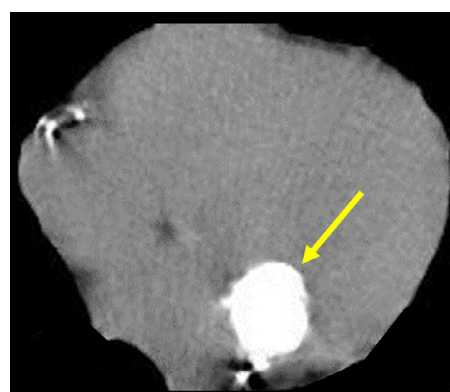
Retrospective review of a noncontrast CT scan performed 6 months earlier for pneumonia (7A) reveals prominent internal calcifications within the mass, compared to a follow-up CT scan after the cerebral infarction (7B).
